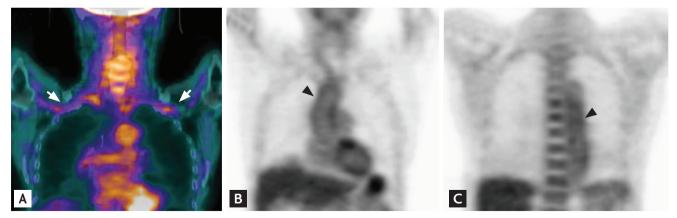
(A) Fusion-coronal and (B, C) coronal images obtained by positron emission tomography (PET). Fluorine-18-fluorodeoxyglucose (FDG)-PET/computed tomography reveals stenosis of both subclavian arteries (A, arrows), and mild linear FDG activity along the wall of the aortic arch (B, arrowhead) and the descending thoracic aorta (C, arrowhead). Such activity is indicative of active vasculitis.
